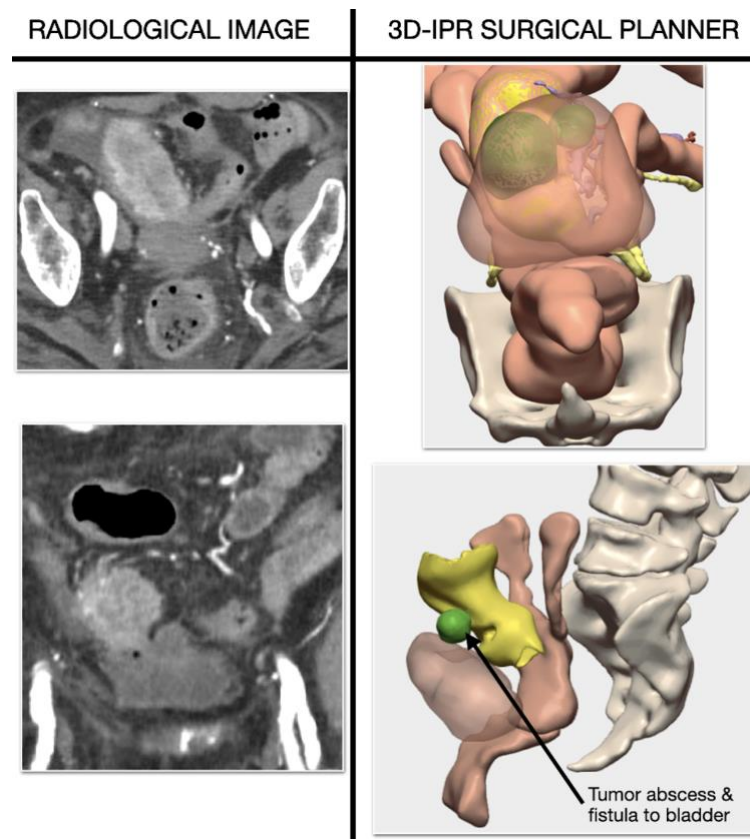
Locally advanced sigmoid colon cancer with an abscess and fistula between colon and bladder. To the left, CT scan does not show plane of separation between tumor and bladder. 3D-IPR shows abscess and fistula bewtween sigmoid and bladder, no tumor infiltration.
